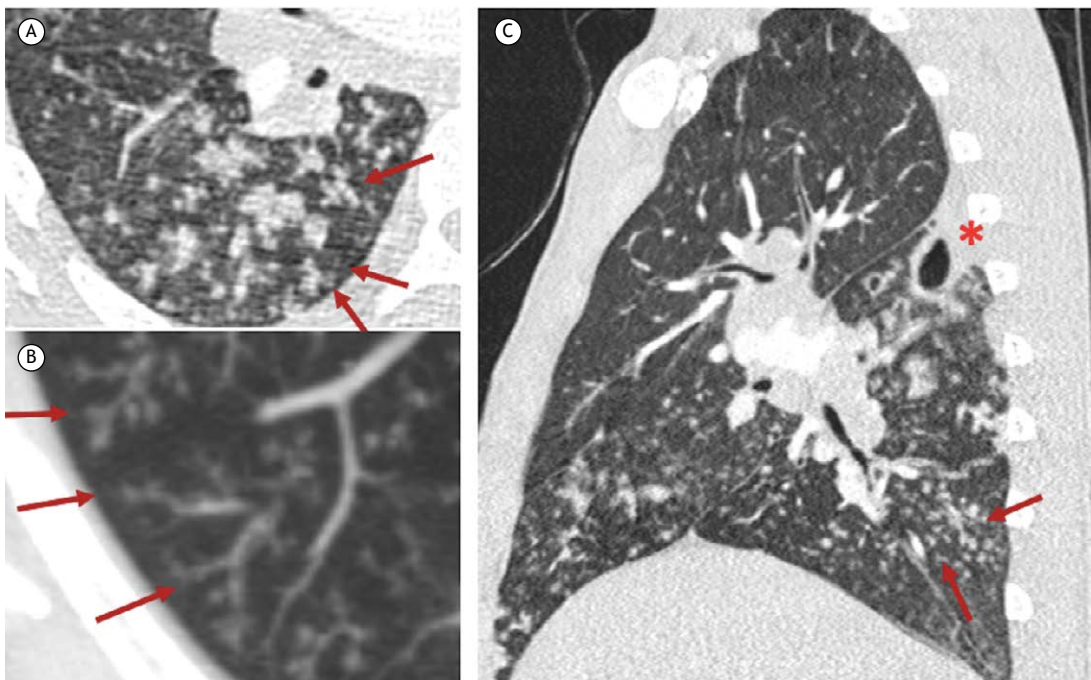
CT scans with lung window settings of a male patient with pulmonary tuberculosis. In A, an axial CT scan showing multiple centrilobular opacities with small nodules and branching structures (arrows). In B, maximum-intensity projection reconstruction demonstrating opacified structures that reflect endobronchial filling of the distal bronchioles (arrows). In C, a sagittal CT scan showing, in addition to centrilobular nodules and a tree-in-bud pattern (arrows), the presence of a cavity in the upper segment of the right lower lobe, which is a characteristic location for cavitation (asterisk) in pulmonary tuberculosis.
